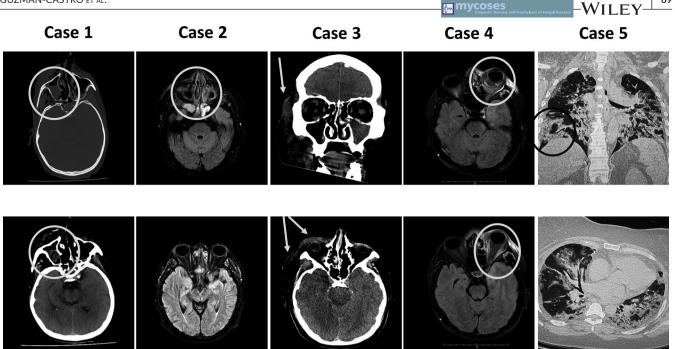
Findings in imaging in patients with CAM. Case 1. CT scan showing pansinusitis, maxillar bone erosion, subcutaneous and intramuscular dissecting gas (white circle), Case 2. CT scan with mucosal thickening at in maxillary and ethmoid sinuses with communication between sinuses and cranial cavity. Case 3. CT scan showing pansinusitis, bone erosion, periorbital and hemi-facial oedema (white arrow), subcutaneous gas, hypodensity in frontal lobes. Case 4. MRI showing left eye proptosis (white circle), postgadolinium enhancing of pre- and periorbital muscles and soft tissues. Sinus thickening and soft tissue dissection. Case 5. Wide bilateral consolidations, air bronchogram, image compatible with reversed halo sign (black circle)
